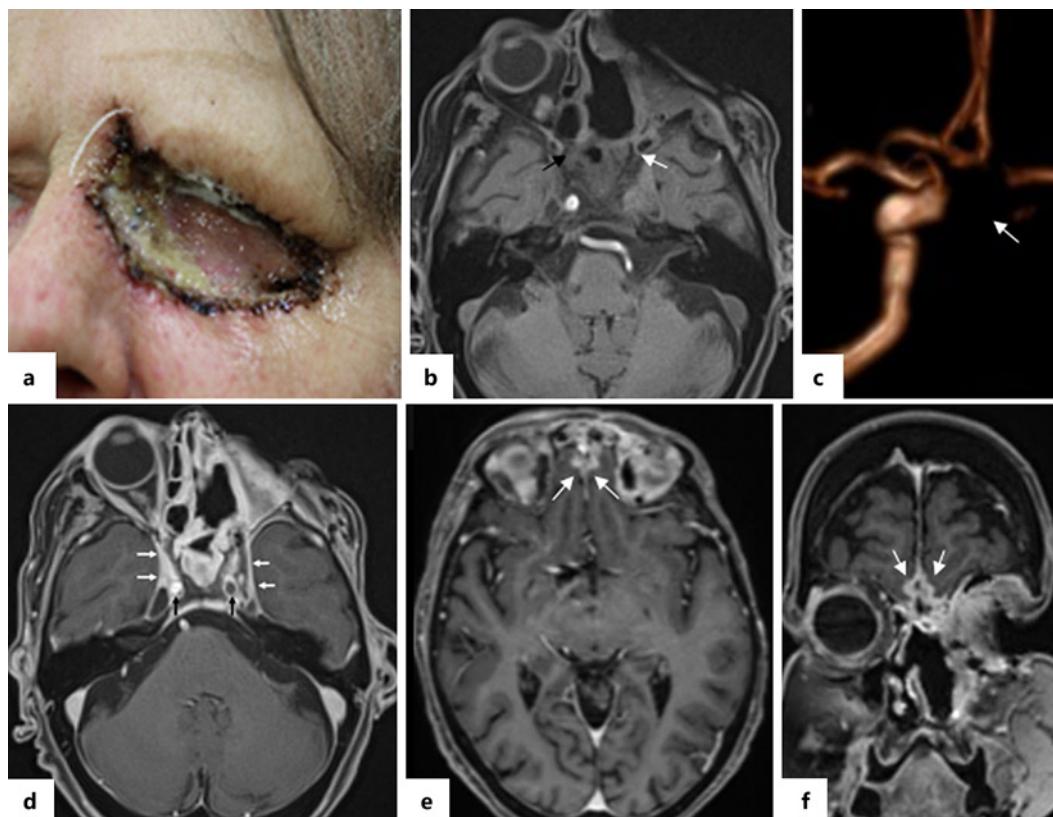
Patient 1: postoperative clinical status and postoperative follow-up MRI after left orbital exenteration. a Clinical follow-up: situation after exenteration of the left orbital cavity. b, c The native axial T1-weighted starVIBE with fat saturation revealed a new filling defect of the left ICA (white arrow in b) in comparison to the normal flow void of the right ICA (black arrow in c). This was correlated in 3D-TOF MRA (arrow in c) confirming occlusion of the vessel. e, f The whole-brain post-contrast T1-weighted multiplanar reconstruction (MPR) (e axial and f coronal) showed perineural spread of the inflammation with extension and contrast enhancement of the frontobasal pachymeninx bilateral (arrows).
